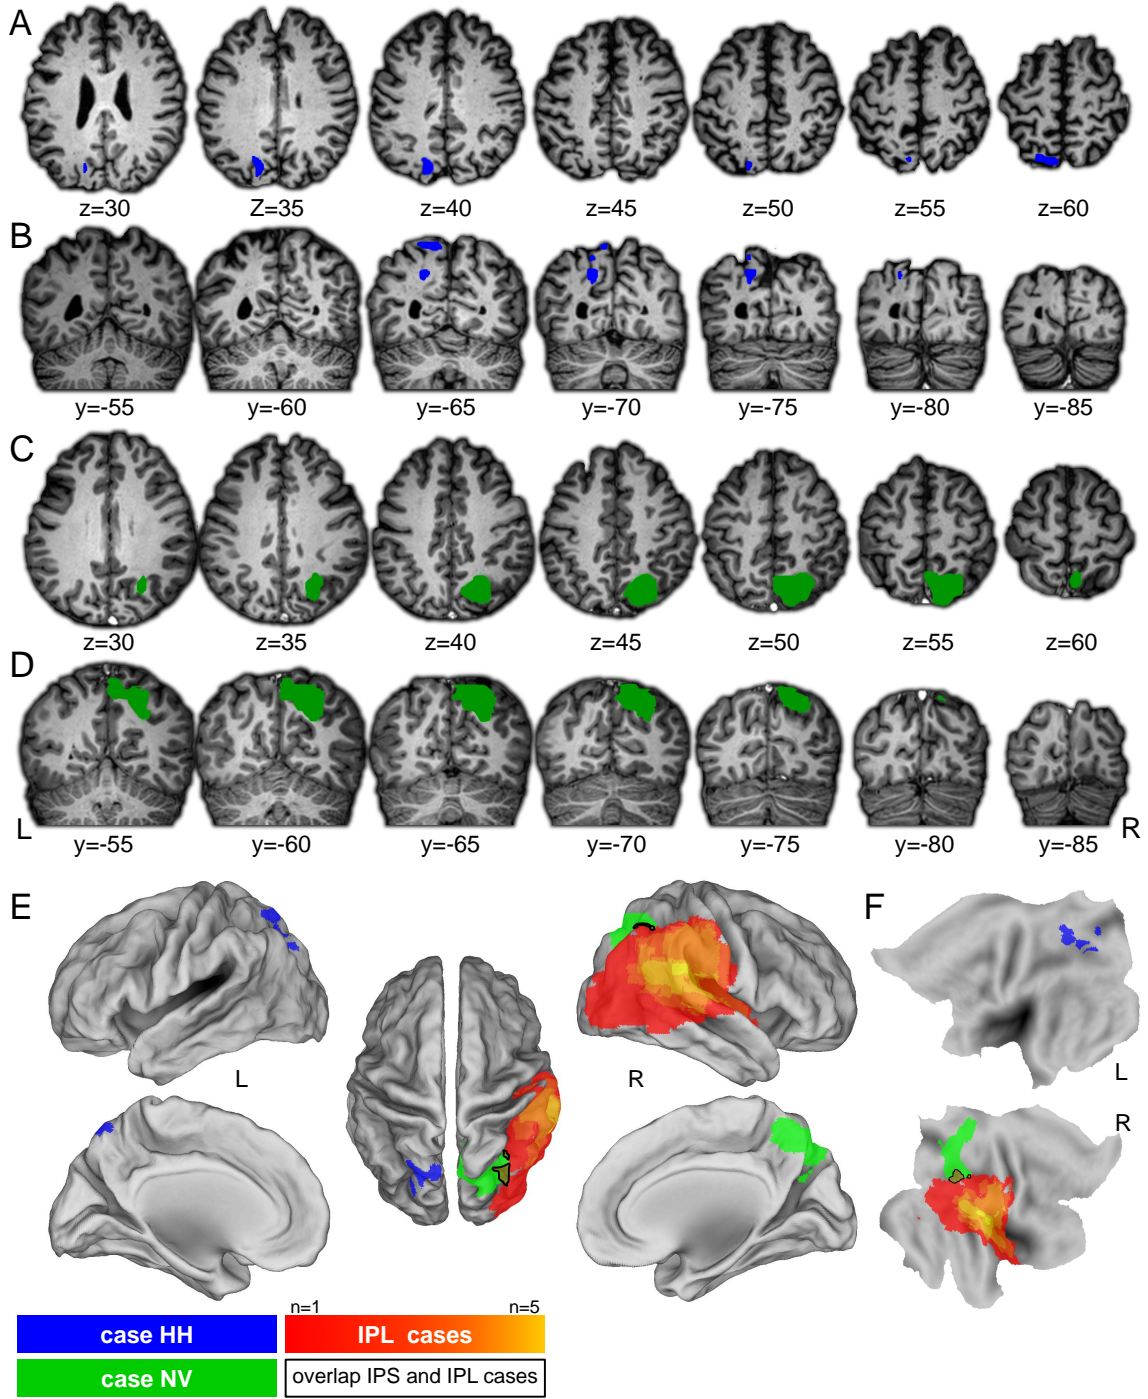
Neuroanatomy of lesions. (A-D) Anatomy of the patients' brain on T1-weighted MR images, normalized to MNI space. The lesions of HH (A,B) and NV (day 4, C,D) are projected on axial (A,C) and coronal (B,D) slices. (E) Lesions in HH, NV and the 5 IPL cases projected onto a surface rendering of the brain (lateral, medial and dorsal view) (PALS Atlas, Caret 5.612 (Van Essen, 2005)). The black outline indicates the lesion overlap between case NV and one of the IPL cases (AN). (F) Projection of the lesions on the flattened brain surface.
